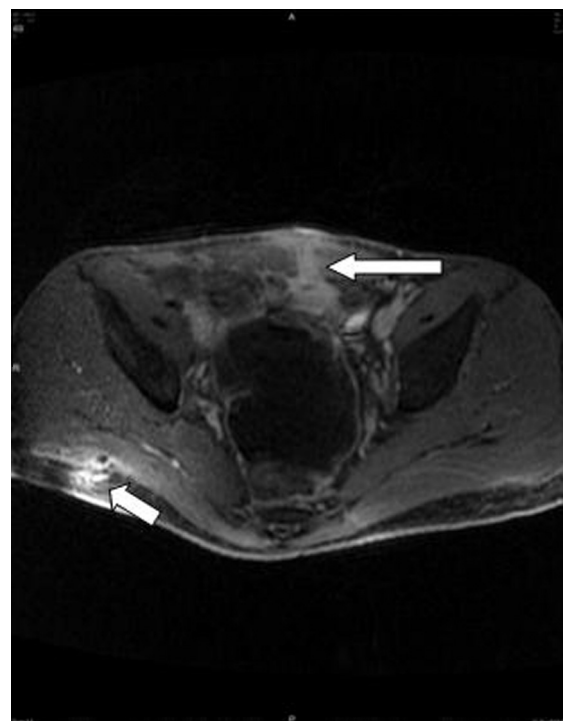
Intra-abdominal abscess in a 29 patient known CD presented with fever and acute abdominal pain. DWI showed intra-abdominal inflammatory mass displaying restricted diffusion (arrow). Finding was confirmed in surgery.
